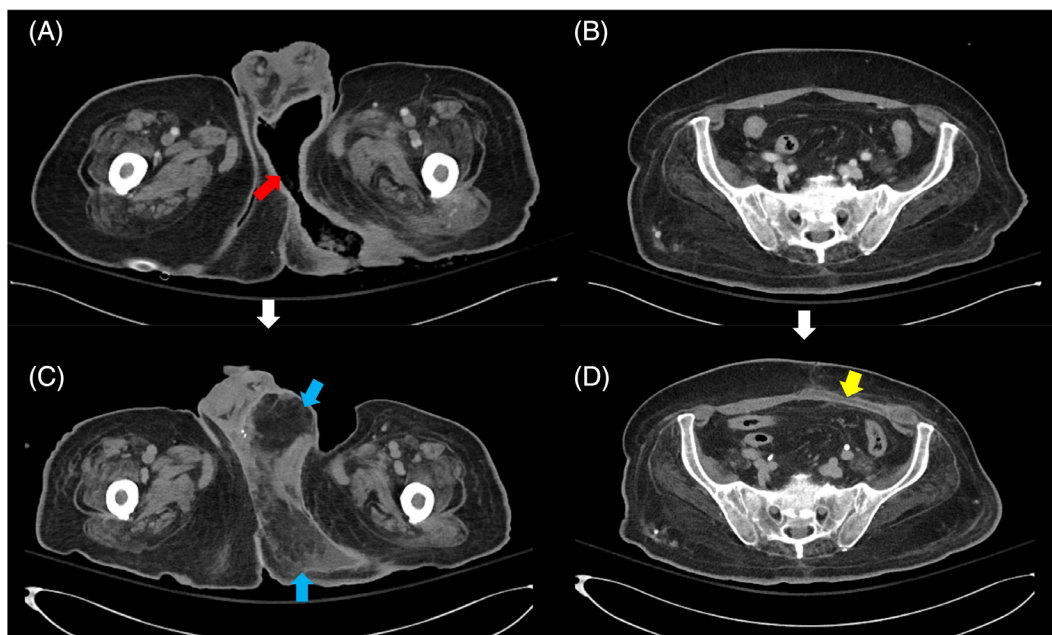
A, B, Preoperative computed tomography (CT) findings showed a soft-tissue defect in his penoscrotal area extending to the left ischial tuberosity (red arrow). C, Postoperative CT findings revealed that the vertical rectus abdominis musculocutaneous (VRAM) flap successfully replaced the soft-tissue defect (blue arrow). D, Postoperative CT findings also revealed that implanted tensor fascia lata allograft is well maintained at the position of the left rectus muscle without a noticeable problem (yellow arrow)
